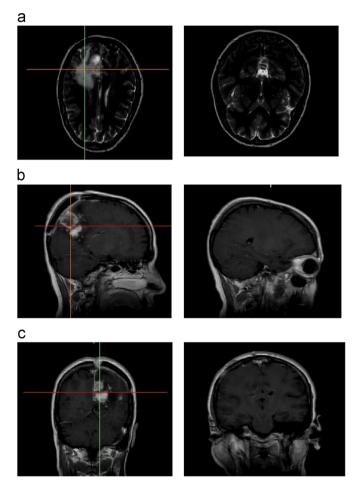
(a) Coronal MRI; (b) sagittal MRI; and (c) axial MRI images of brain; please note the view of tumor in left pictures.
